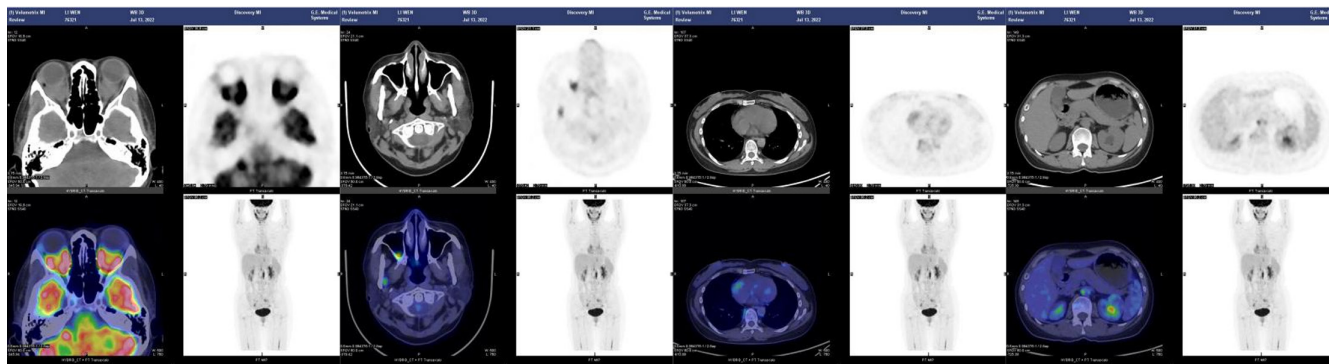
Case one PET/CT scan imaging. Soft tissue mass in bilateral posterior eyeball muscle cone, abnormal radioactive concentration was observed on PET imaging.
